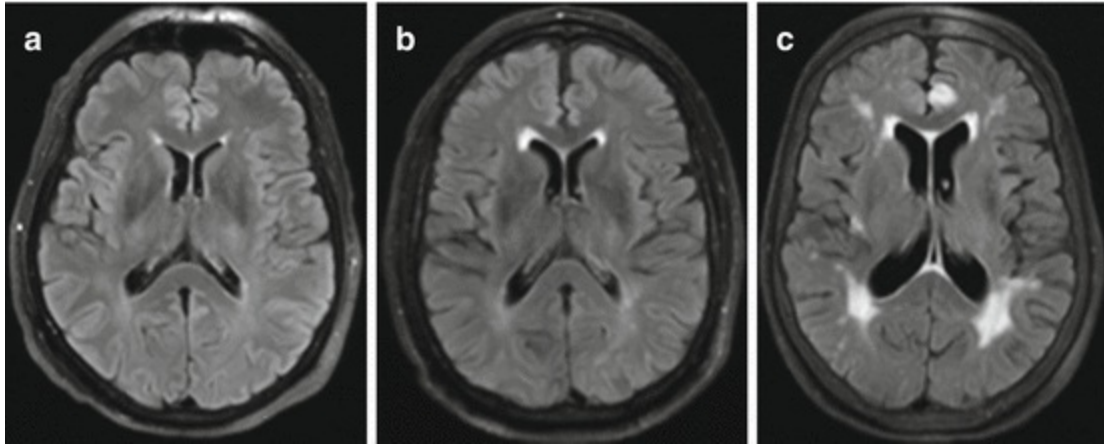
White matter hyperintensity on 3T MRI. The burden of underlying cerebrovascular disease in adults can be visualized using T2 FLAIR MRI, which demonstrates mild (a), moderate (b), and severe (c) leukoaraiosis involving both periventricular and subcortical areas of the white matter. Severity and topographical distribution of WMH varies depending on pathophysiology of the primary process; however, the small cerebral vessel pathology is often implicated in both sporadic and hereditary syndromes (Courtesy of Dr. Rost)
